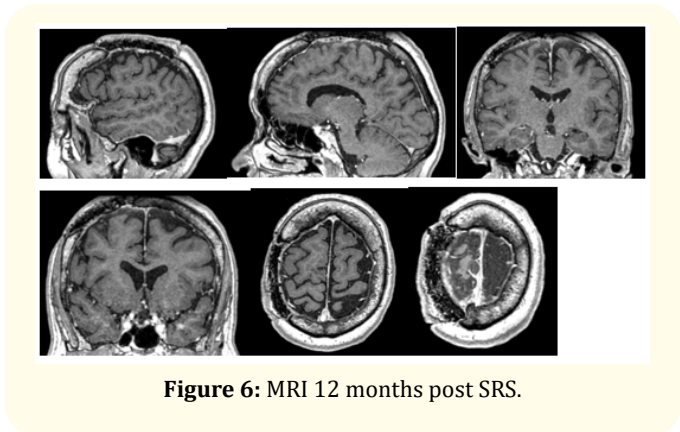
MRI 12 months post SRS.
